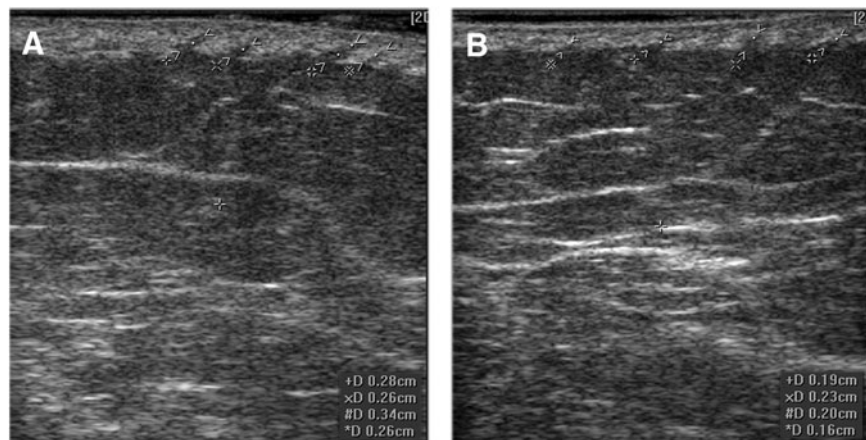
Ultrasound images at the beginning (A) and end (B) of the study, indicating the reduction in the length fascicle.
